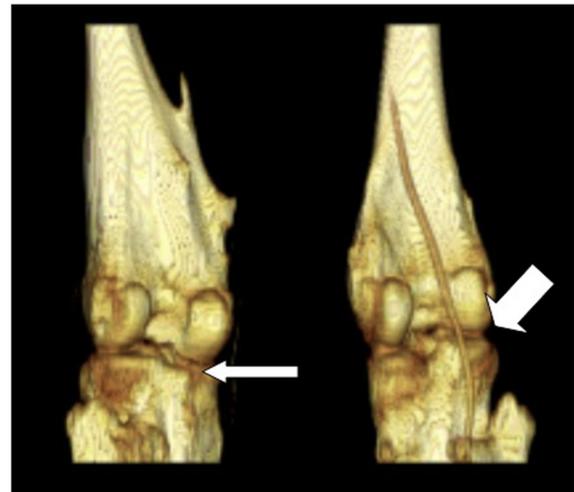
Three-dimensional reconstruction of CT angiogram demonstrating absence of contrast uptake in the left popliteal artery (thin arrow) and contrast enhancement of the right popliteal artery (thick arrow).
